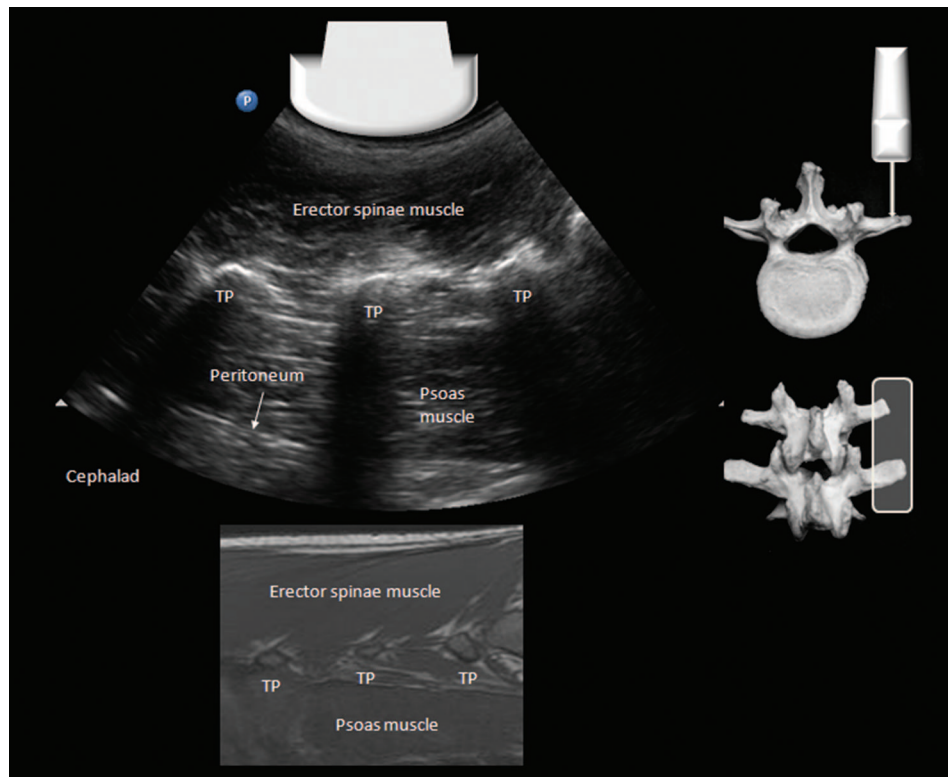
Paramedian sagittal transverse process view of the lumbar spine and corresponding magnetic resonance imaging (MRI) scan (T1-weighted). The probe is placed over the tips of the transverse processes (TP), which appear as hyperechoic curvilinear structures with “finger-like” acoustic shadowing beneath. This appearance is also called the “trident sign.” The erector spinae muscle and the psoas muscle lie superficial and deep to the transverse processes, respectively. The peritoneum often is visible if the depth setting is increased appropriately. (Image used with permission from www.usra.ca.)
